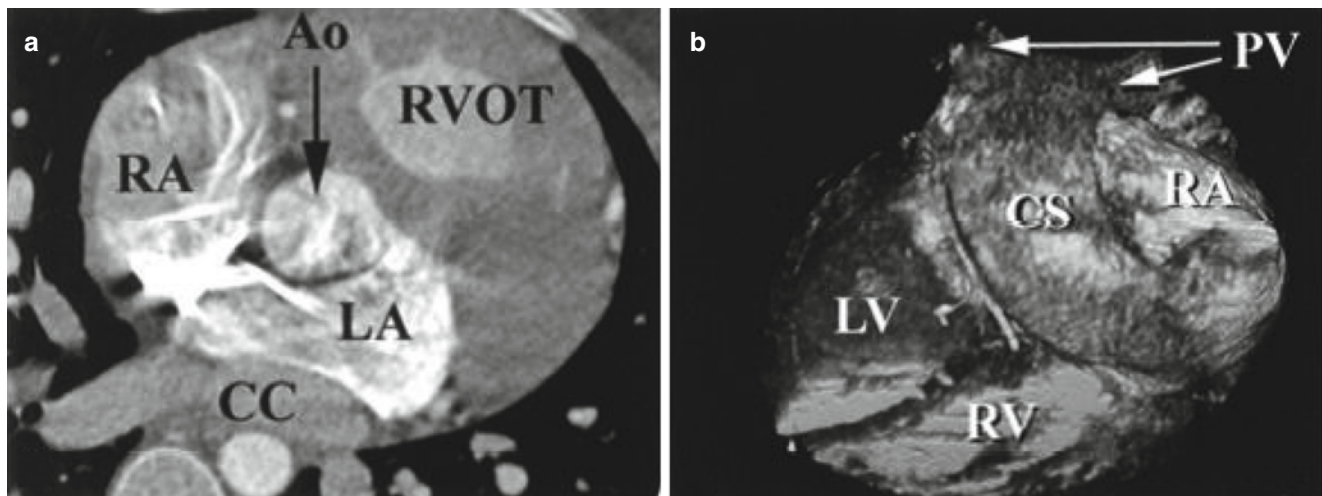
Contrast-enhanced electron beam computed tomography (EBCT) study axial slices in a 33-year-old woman with a secundum atrial septal defect (ASD) [2]. (a) Prior to closure, the left superior pulmonary vein (LSPV) drains normally to the left atrium (LA). The ASD
